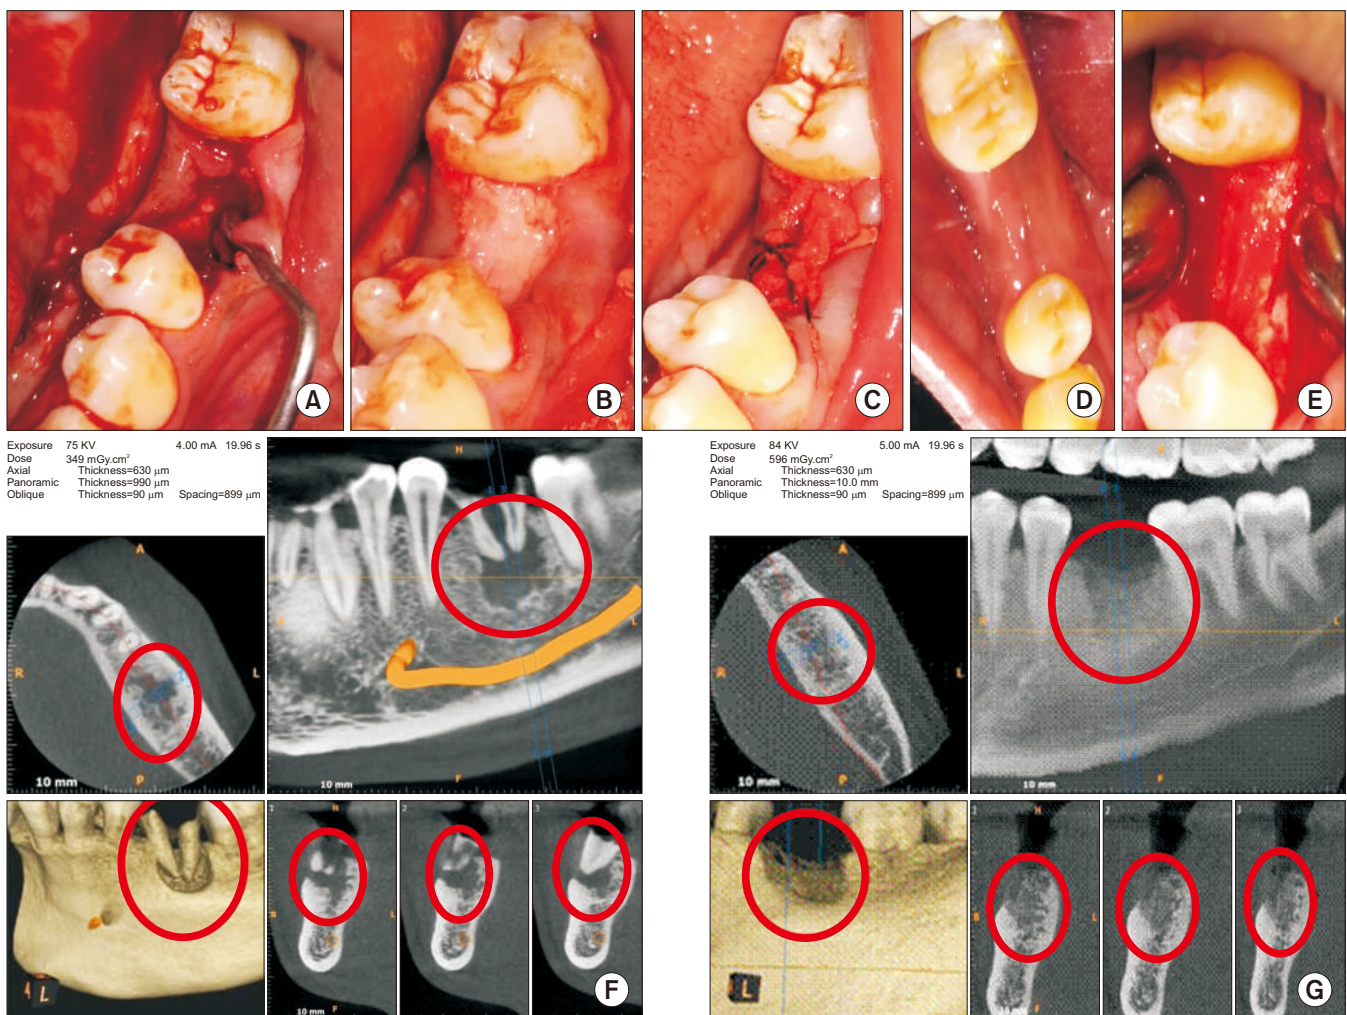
A. Bone defect immediately after extraction with curette in place. B. Bone graft material placed till crestal level in the mandibular left first molar socket. C. Wound closure using platelet-rich fibrin membrane and figure of eight suture. D. Well healed wound after two weeks. E. Well-formed bone observed during exposure for implant bed preparation. F. Cone-beam computed tomography pre-extraction view with roots and bone defect marked in red circles. G. Bone formation (red circles) assessed before implant placement.
